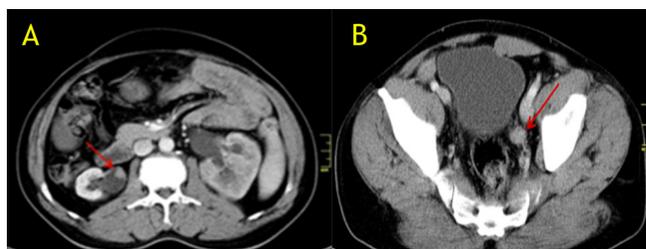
Preoperative contrast-enhanced CT images of the right renal pelvis (A) and left distal ureteral (B) tumor (red arrow)
